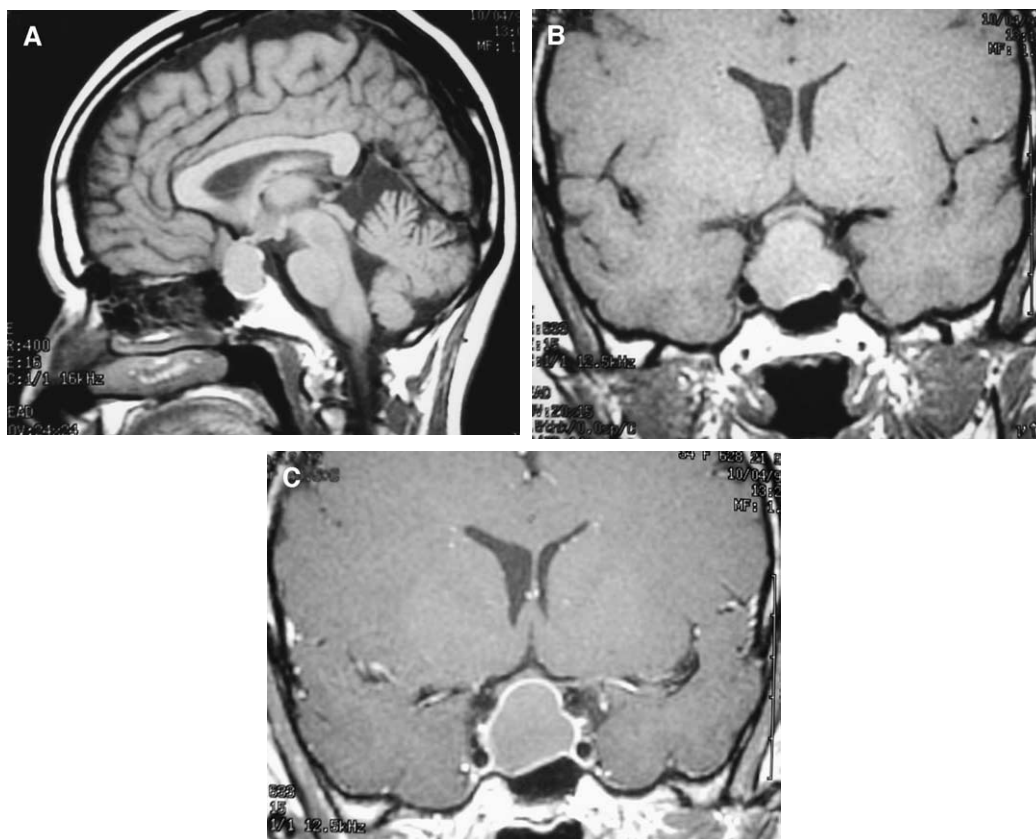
Pituitary macroadenoma. (A) Sagittal T1-weighted image show a large isointense mass in the enlarged sellar turcica with suprasellar and infrasellar extension. (B) Coronal T1-weighted image demonstrates a large sellar mass with suprasellar extension and compression of the optic chiasm. The mass appears to extend into the cavernous sinuses bilaterally. (C) Coronal postcontrast T1-weighted image demonstrates enhancement of the mass as well as enhancement of the peripheral rim.
